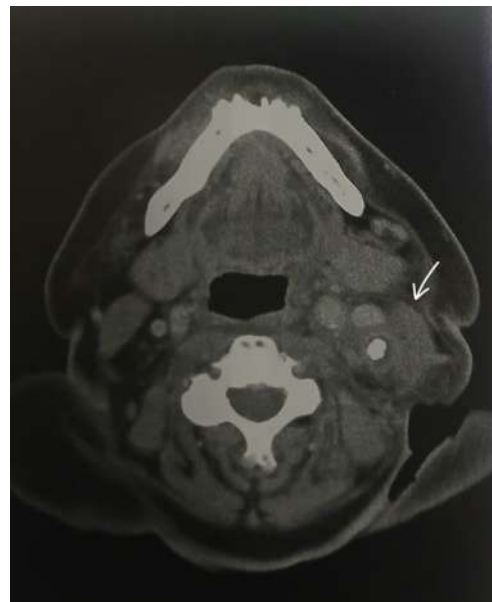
CT neck showing left anterior cervical chain mass
